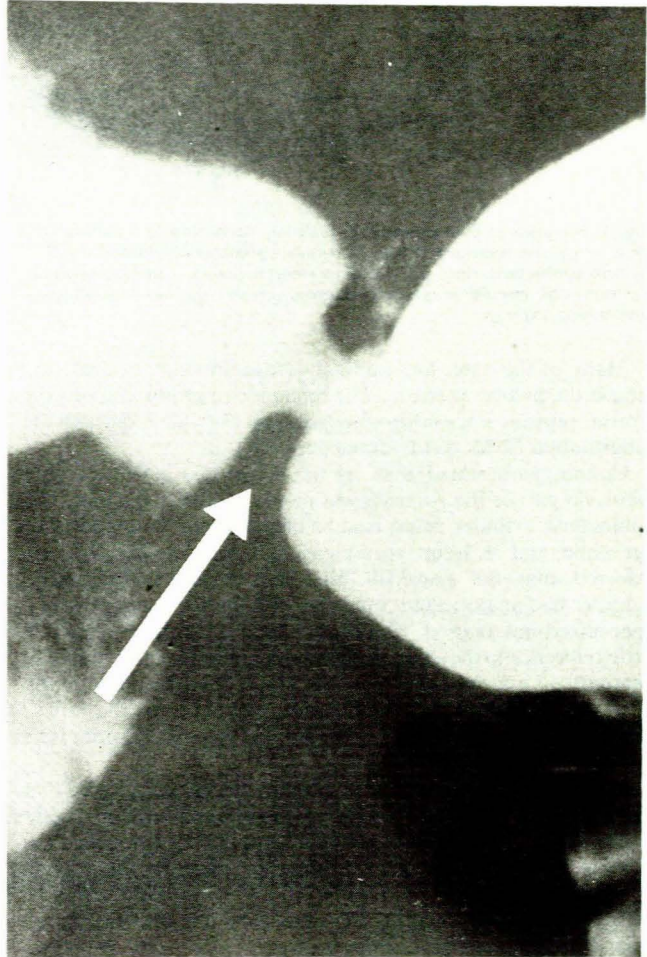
Radiograph showing pyloric ring (arrowed). The ring is usually equated with the pyloric sphincter.
